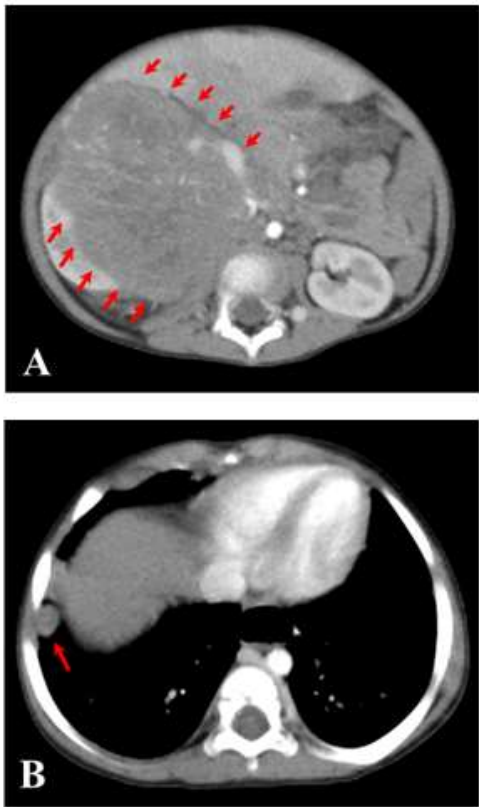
Axial CT Scan of the chest and abdomen without contrast-enhanced. (A): Right heterogeneous enhancing mass lesion with extension to the kidney at the same side, that had crossed mid-line with no obvious calcification. (B): Two nodules with a diameter of 12 mm in right lung showing secondary pulmonary metastatic lesions of mass.
